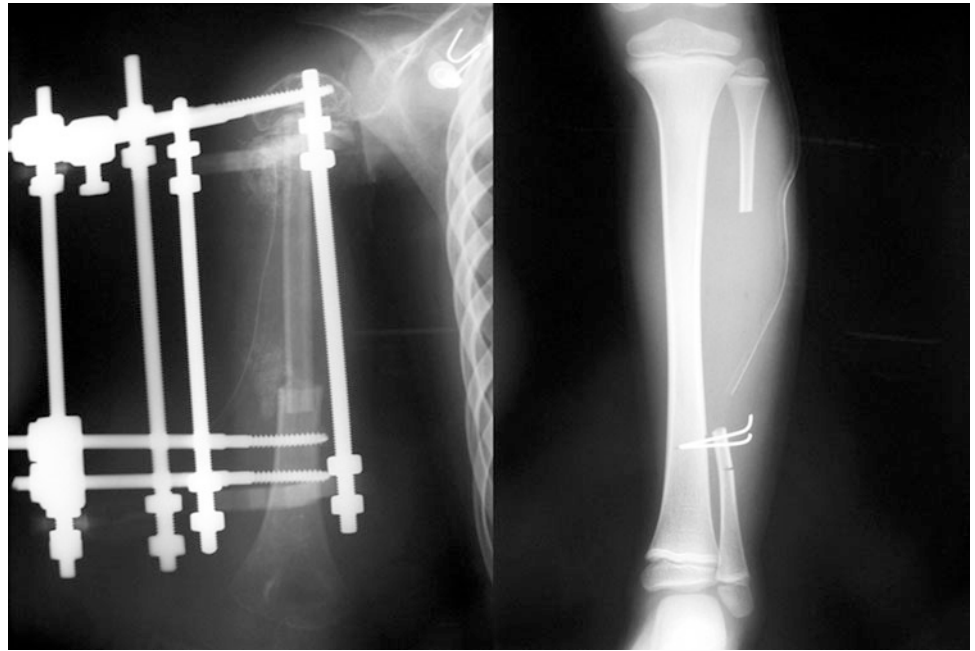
(a, b) Radiographs and bone scan 3 months after surgery
